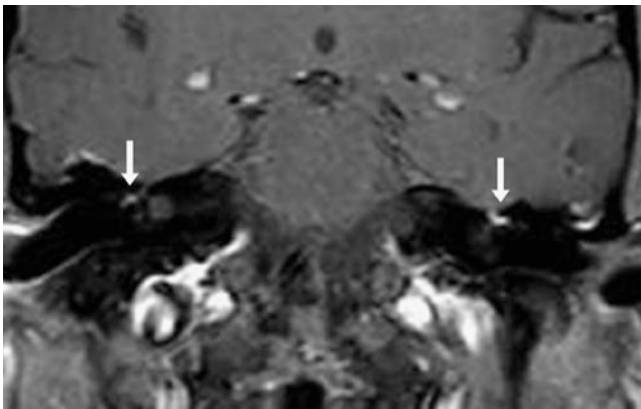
A 62-year-old patient with a negative 3 T MRI for metastases. A coronal postcontrast FS SET1WI shows avid, asymmetric enhancement of the left geniculate ganglion (*arrows*); the enhancement on the right side is much milder
